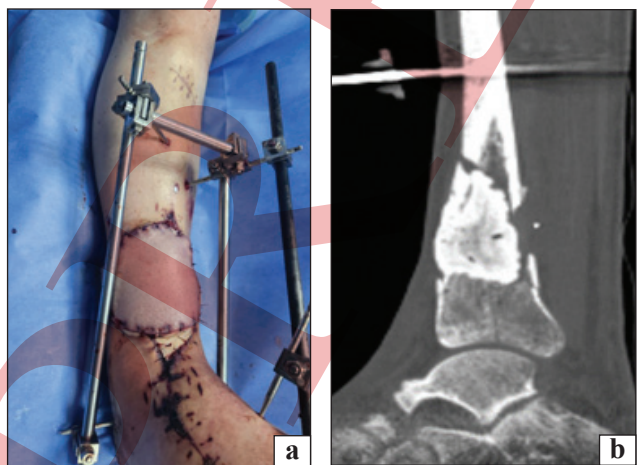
Soft tissue defect closure (a); radiographic images after cement spacer insertion (b)
